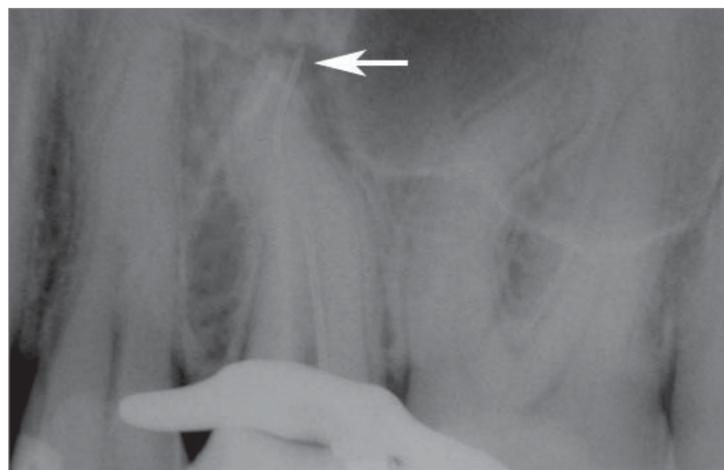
In the case above, the Micro did not initially draw irrigants and a check X-ray demonstrated the Micro's tip extended into the periapical tissue 0.75 mm. Once the tip was withdrawn 0.75 mm it functioned properly. Note: The "S" shaped curve to the Micro. The Fingerpiece was required to provide the necessary proprioceptive sensitivity necessary to guide the Micro to full working length.
